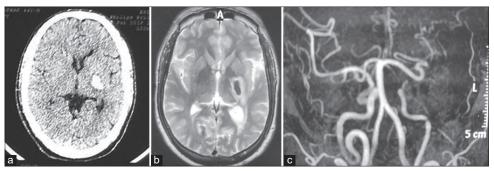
a) Axial non-contrast CT image showing a hyperdense hematoma with surrounding hypodense perilesional edema in the left basal ganglia region extending into the internal capsule and thalamus. b) Axial T2 W MR image showing a hypointense hematoma with surrounding hyperintense edema in the left basal ganglia region extending into the internal capsule and thalamus. c) Coronal MR angiography image showing stenosis of the cavernous segment of the left internal carotid artery with non-visualization of the left middle and anterior cerebral artery with the presence of multiple collateral channels.
